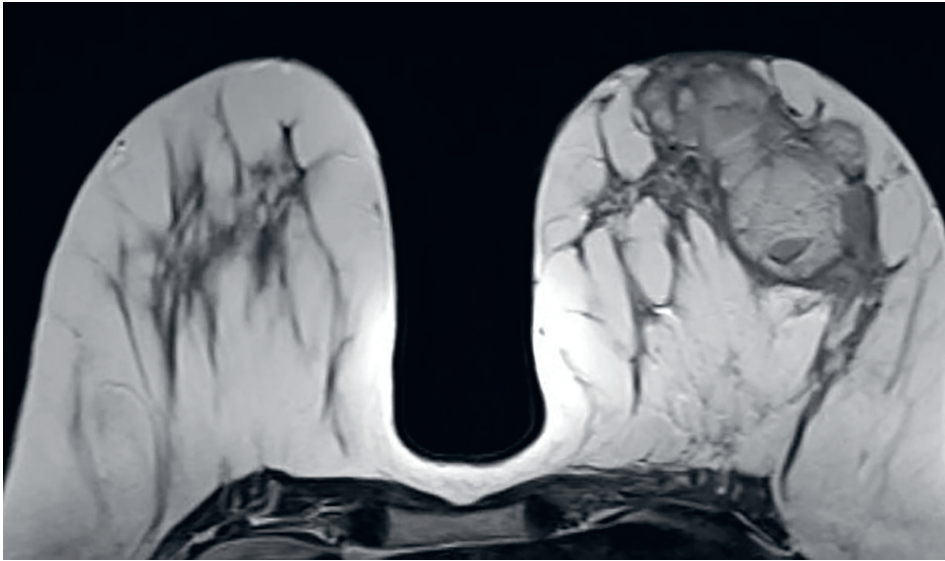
Magnetic resonance image (MRI) of idiopathic granulomatous mastitis (IGM)
